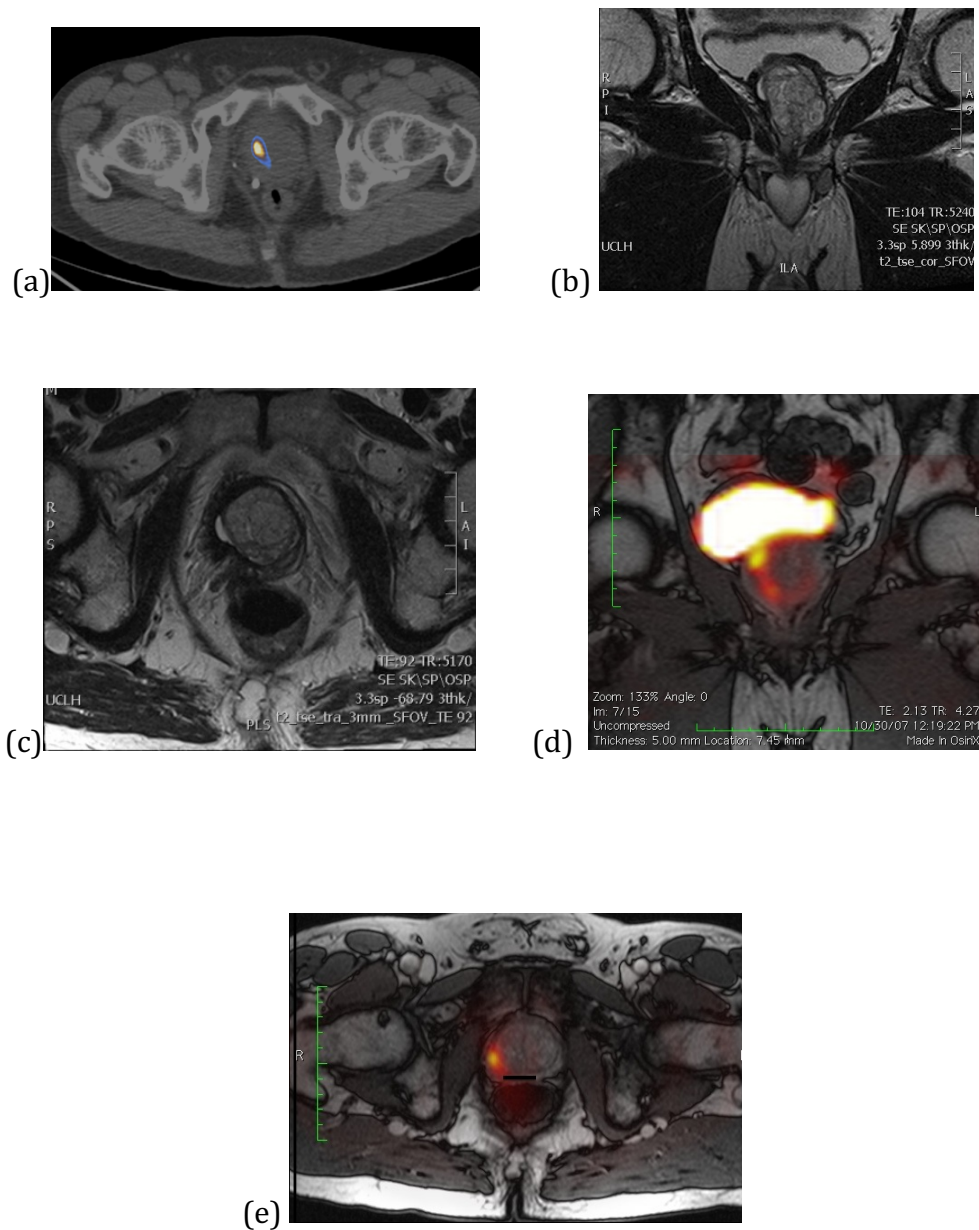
(a-e): (a) axial ^{18}F Choline PET/CT (b-c) coronal and axial MRI prostate (d-e) fused ^{18}F Choline PET/MR prostate. HIFU can alter the anatomical configuration of prostate with cavitation, reduction in volume and periprostatic stranding. The uptake seen in (a) was noted to be a false positive finding as the appearances represent post HIFU cavity with excretory activity easily identified on PET/MR.
